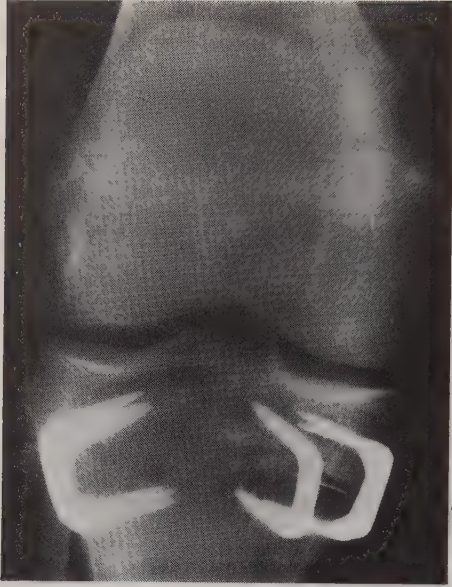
a and b. Case 1. Standard radiographs of right knee at time of extraction of staples. a) AP view; b) lateral view.
